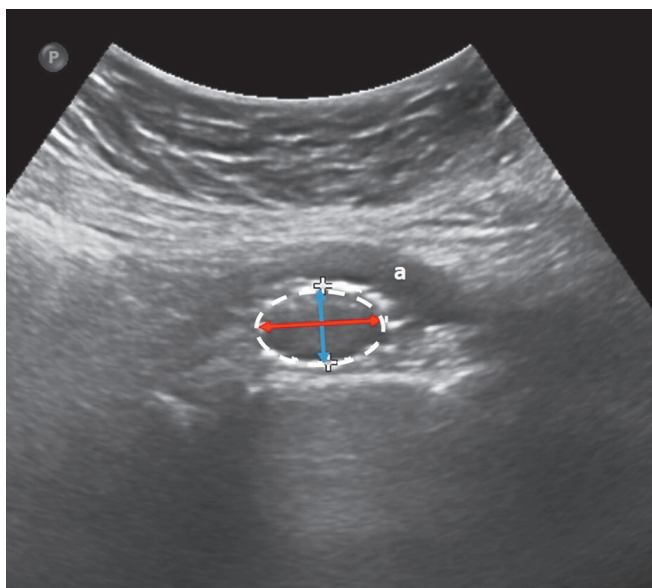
Ultrasound images in a patient with May-Thurner Syndrome treated using a stent with a diameter of 16 mm. External compression due to overriding right common iliac artery (A) results in an elliptical shape (dotted line) and decrease in intraluminal area (measured: 1.57 cm<sup>2</sup>, expected: 2.01 cm<sup>2</sup>). Short axis (vertical arrow): 1.12 cm, long axis (horizontal arrow): 1.79 cm.
